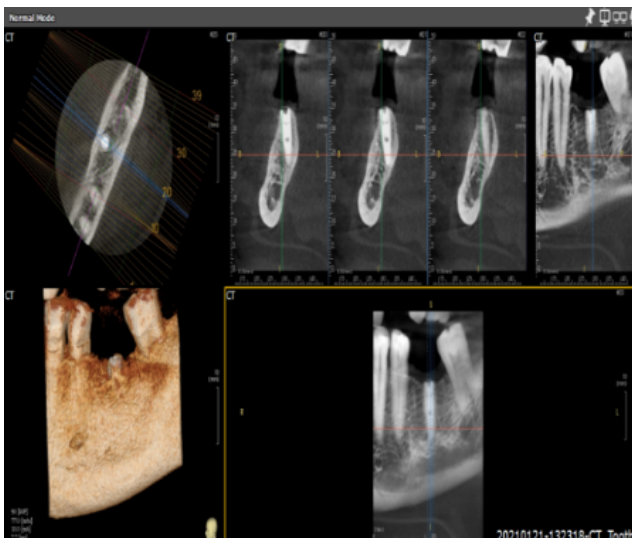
Post-operative CBCT (immediately after implant placement)
